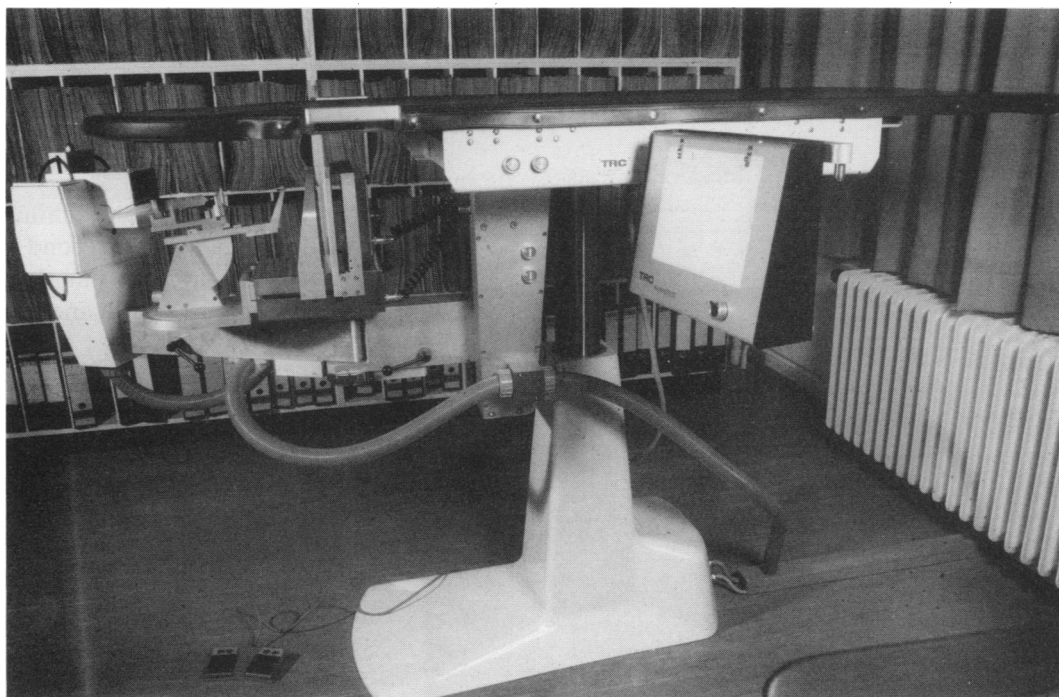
TRC Mammotest device (Taby, Sweden) with its console and a table top on which the patient lies. The x-ray tube (left side) is attached to a hinged arm in front of the puncture device and the film holder.
